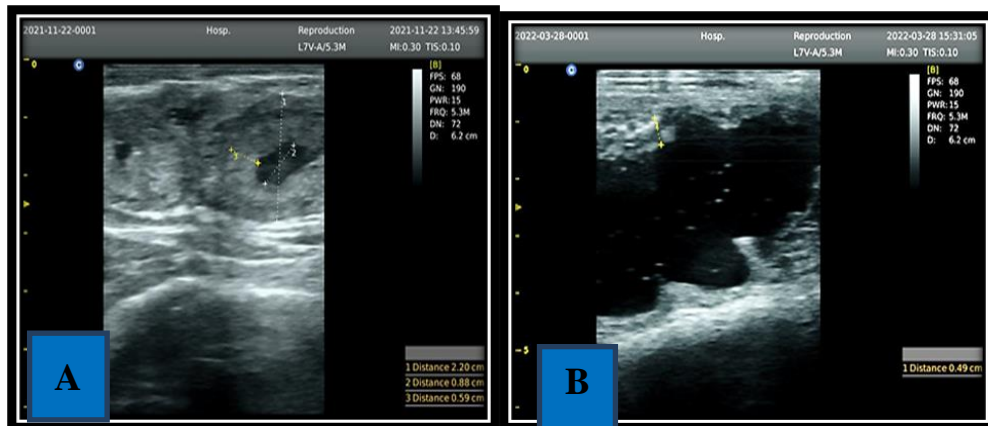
A- Ultrasound images show uterine horns show the inflammatory fluids that appear high echoic in true anestrus, B- show uterine horns show the inflammatory fluids that appear low echoic in PPA using a 5 MHz trans rectal transducer
